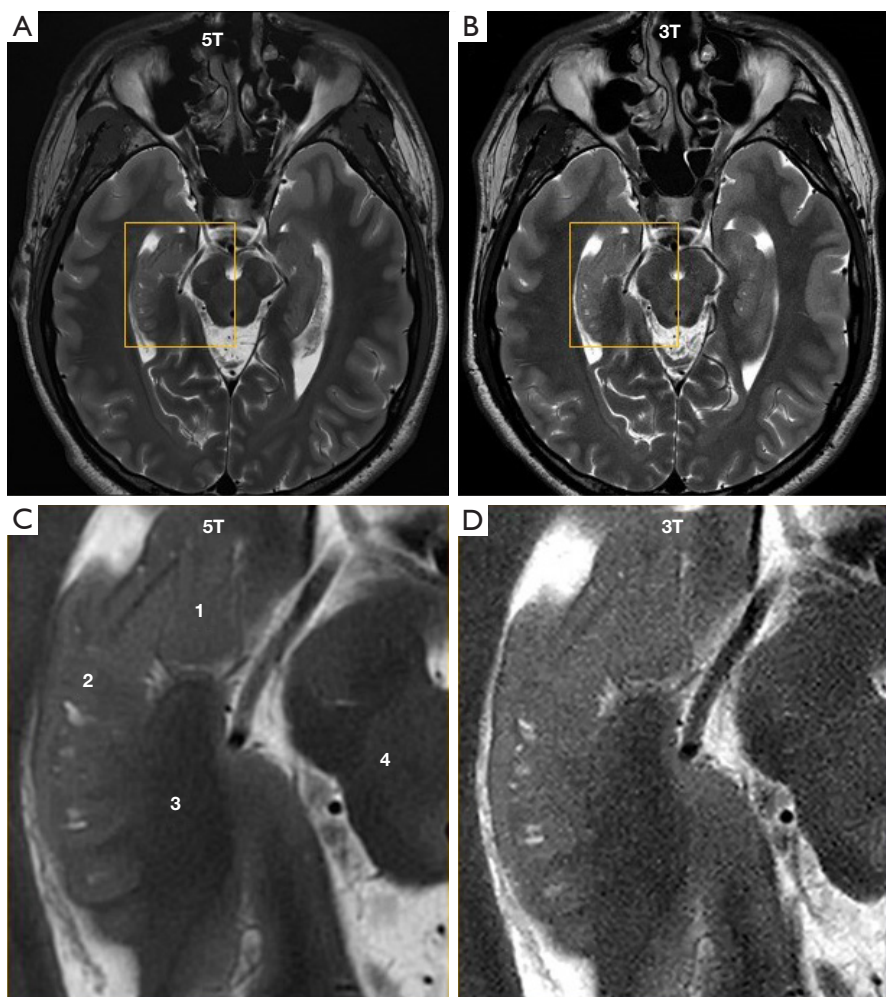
T2-weighted fast spin echo brain images of a healthy volunteer (37 years old; male; 170 cm; 70 kg). The images were acquired with an acquired resolution of $0.3 \text{ mm} \times 0.3 \text{ mm} \times 2.5 \text{ mm}$ at 5T (A) and 3T (B). Magnification of the hippocampal area (yellow rectangles) from the 5T image (C) and the 3T image (D). 1: hippocampal head; 2: hippocampal body; 3: hippocampal tail; 4: mesencephalon.
